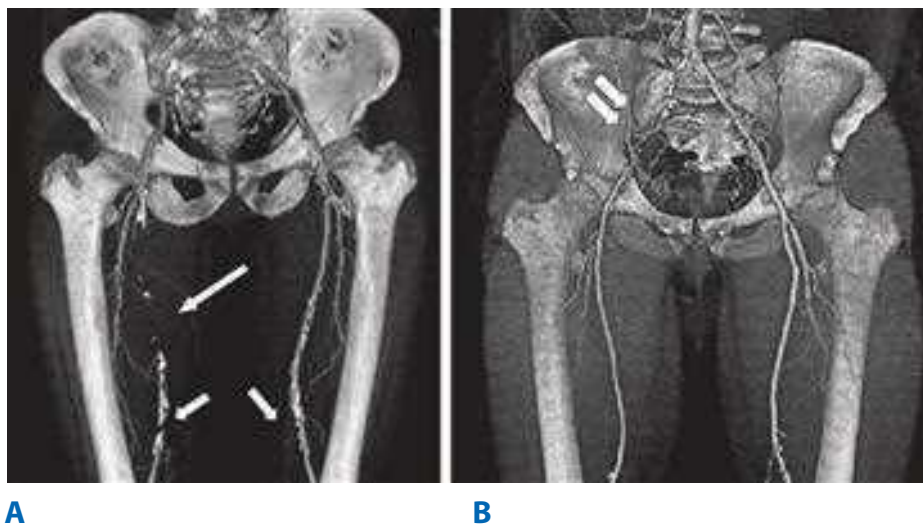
A multidetector computed tomography angiography with three-dimensional reconstruction of the iliofemoral arterial circulation in two patients with lower leg claudication. A. A 50-year-old male with an occluded right superficial femoral artery (*single long arrow*) with reconstituted superficial femoral artery at the level of mid-thigh. Arterial calcifications (*single short arrows*) are present in the bilateral distal superficial femoral arteries. B. A 53-year-old male with occluded right common iliac artery (*double arrows*).
